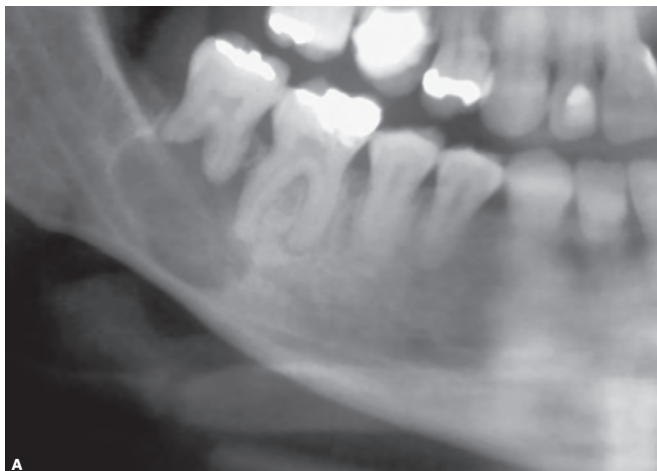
Ameloblastomas in periapical region of mandibular molars. Note root resorption.
